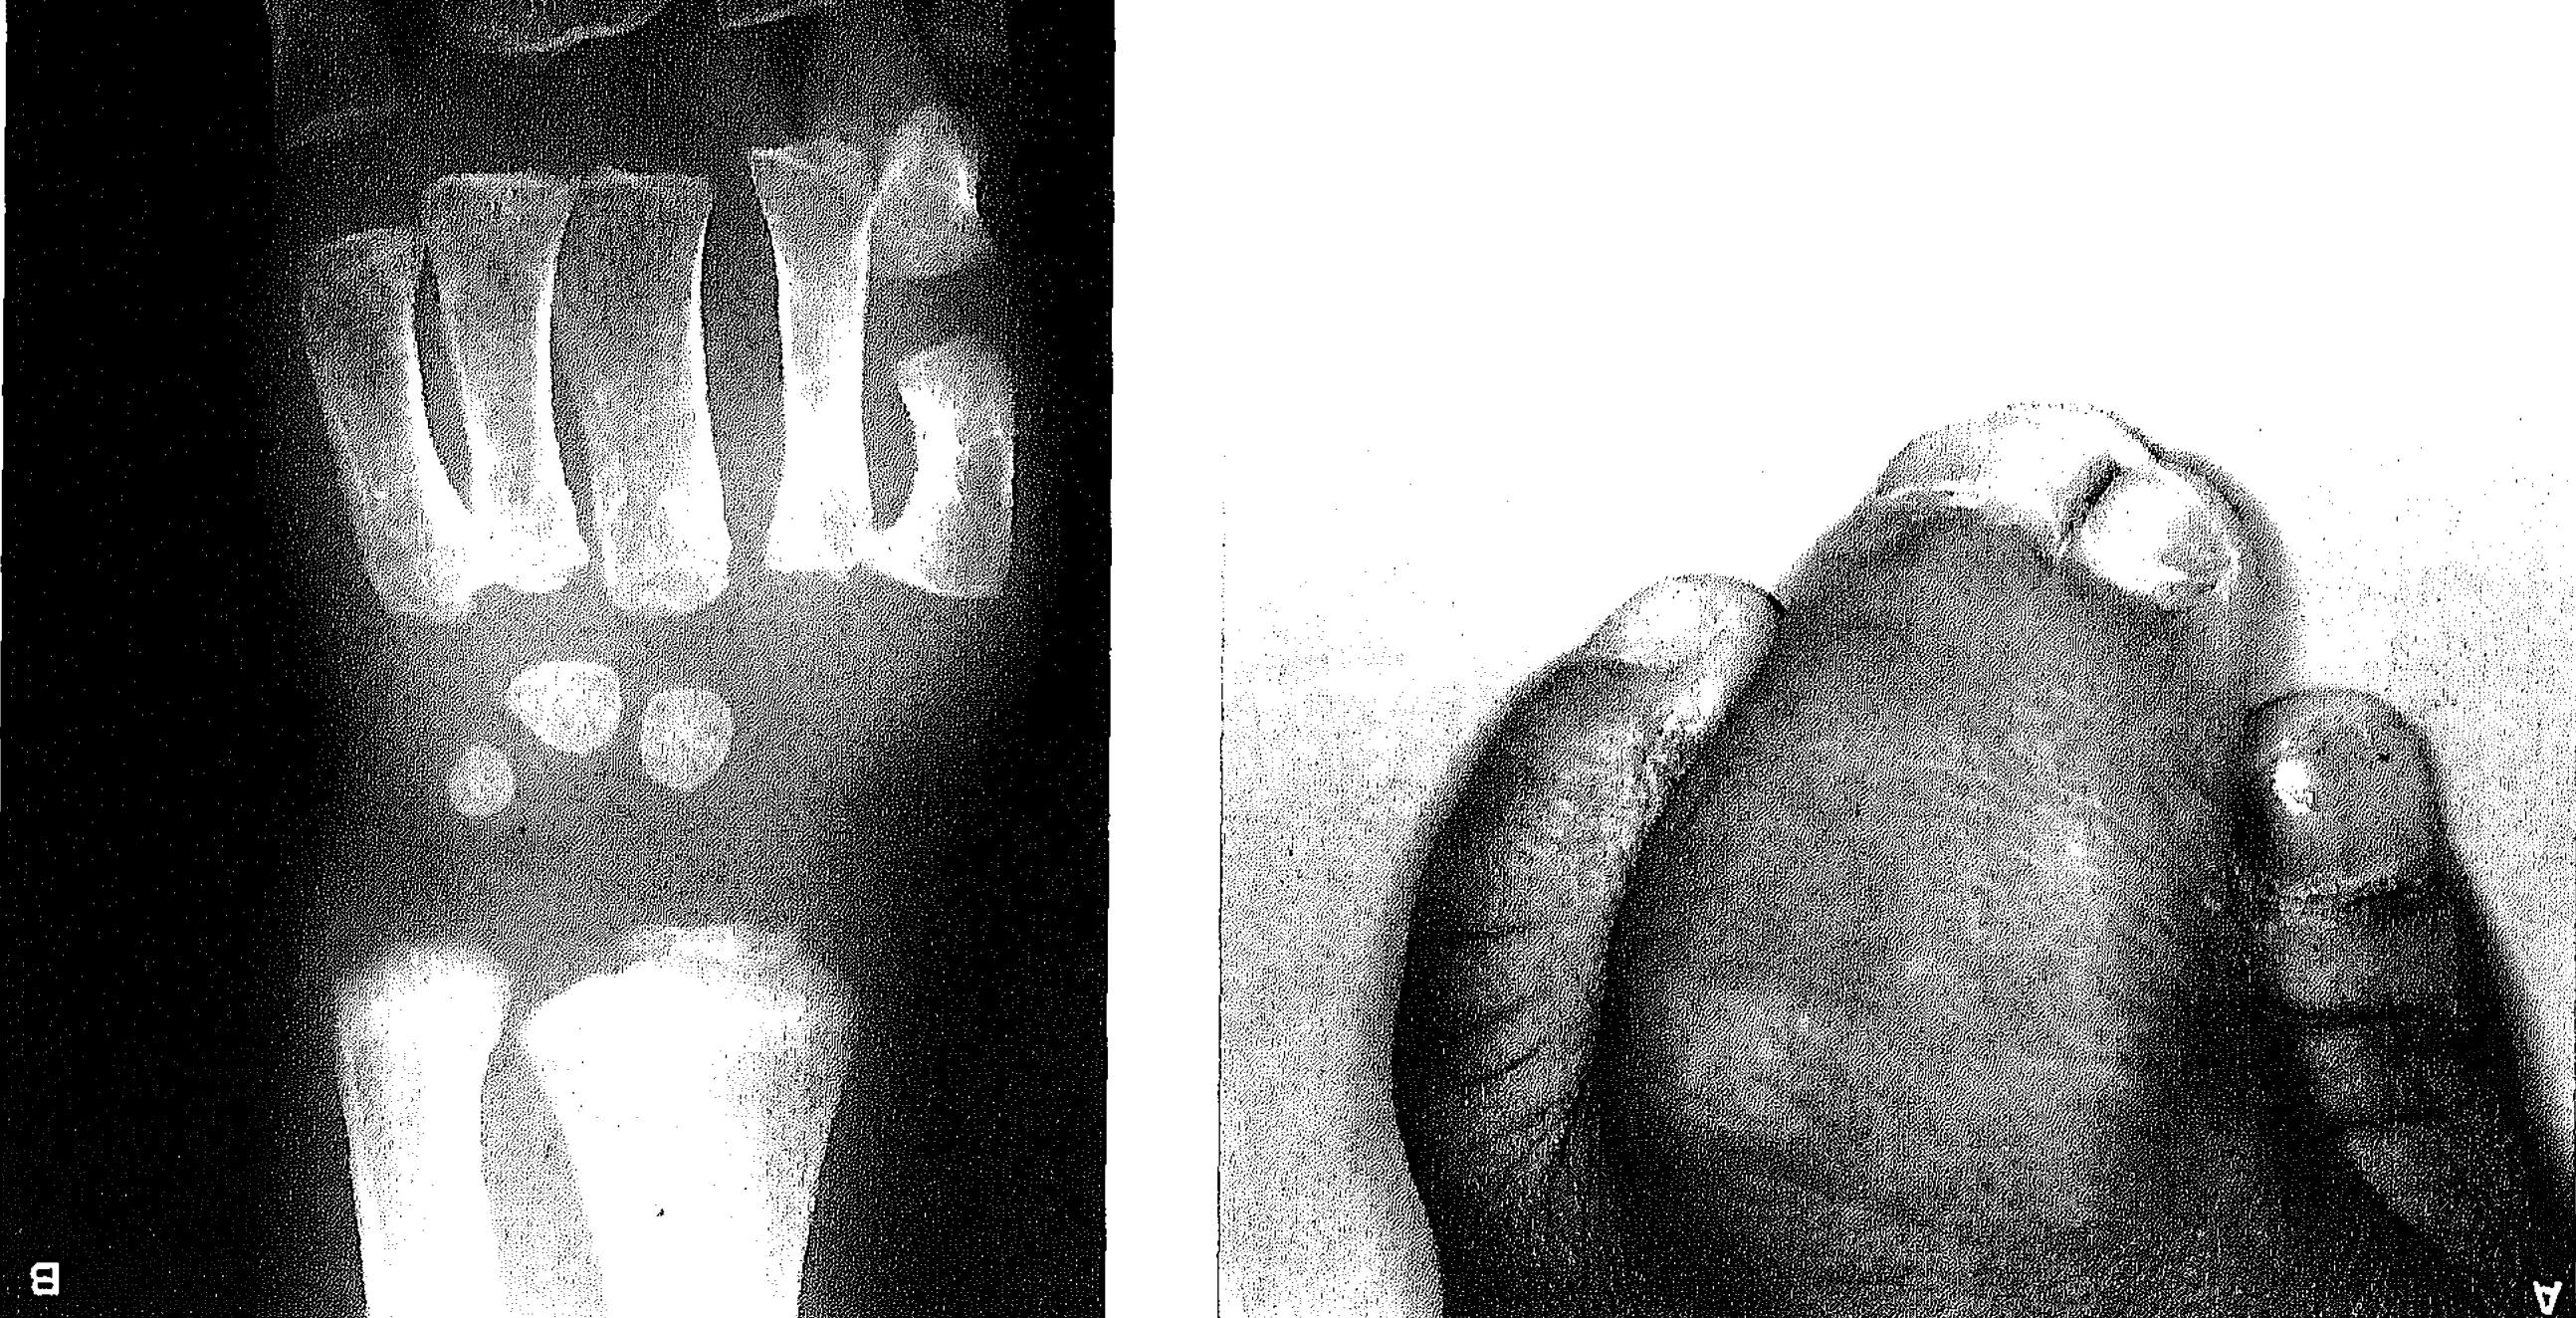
Left hand. A: Cutaneous syndactyly of digits 2–4 and synonychosis of digits 2–4. B: Radiograph showing synostosis of phalanges 3 and 4 and broad metacarpals.
